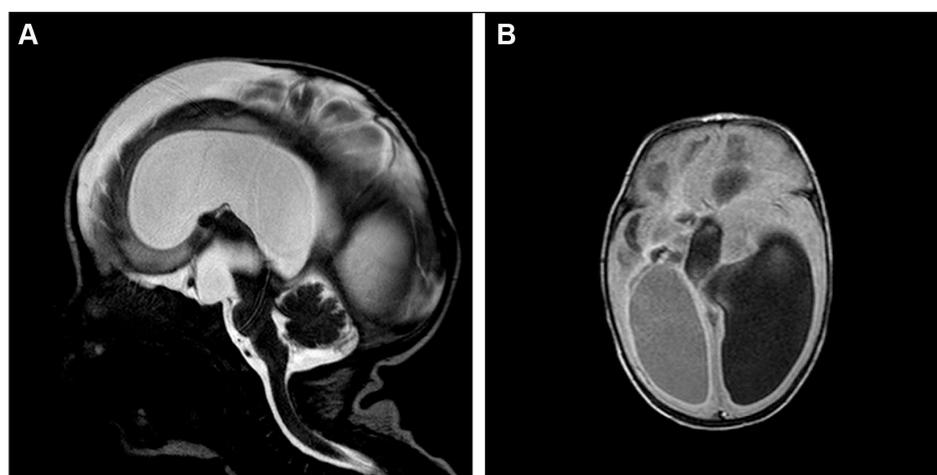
MRI sagittal CSF drive scan and axial FLAIR scan. MRI sagittal CSF drive scan (A) and axial FLAIR (B) scan showing slight aqueductal obstruction associated to large left ventricular system that compress contralateral ventricle and the third ventricle, with marked brain tissue loss, abnormal gyri and fluid flap at convexity.
